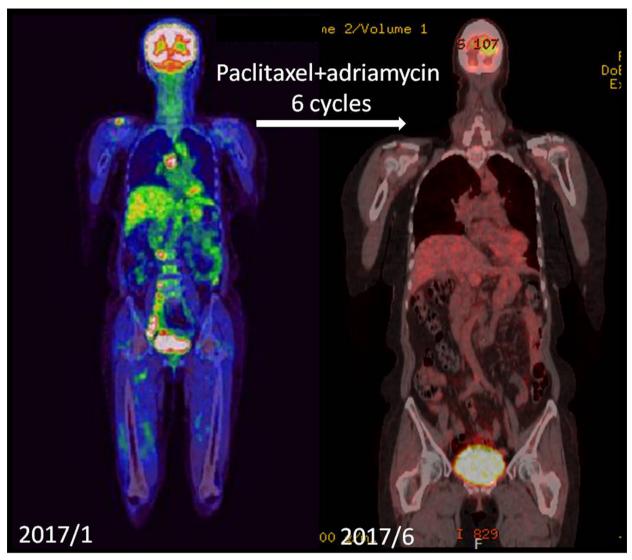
Positron emission tomography – computed tomography scan which followed after 6 cycles of Adriamycin and paclitaxel combination regimen showed disappearance of all metastatic lymph nodes in mediastinal and para-aortic regions.
